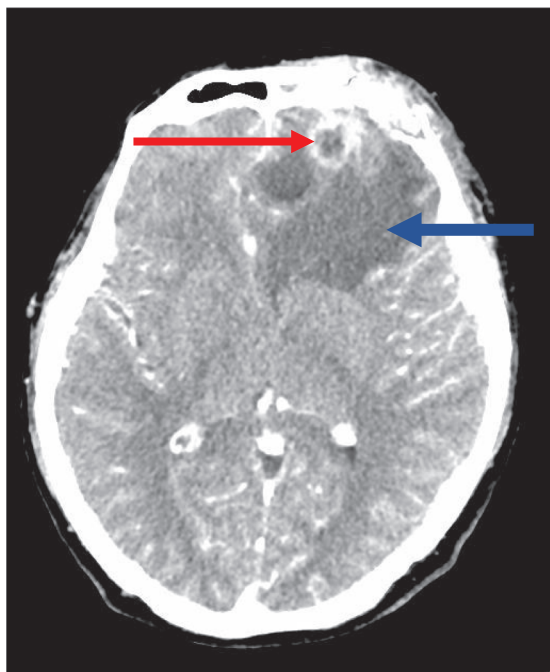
Contrast-enhanced CT scan, 13 days after the dental procedure. Collections in the left frontal lobe (The blue arrow indicates the abscesses, and the red arrow indicates the white ring enhancement, due to the contrast used).
